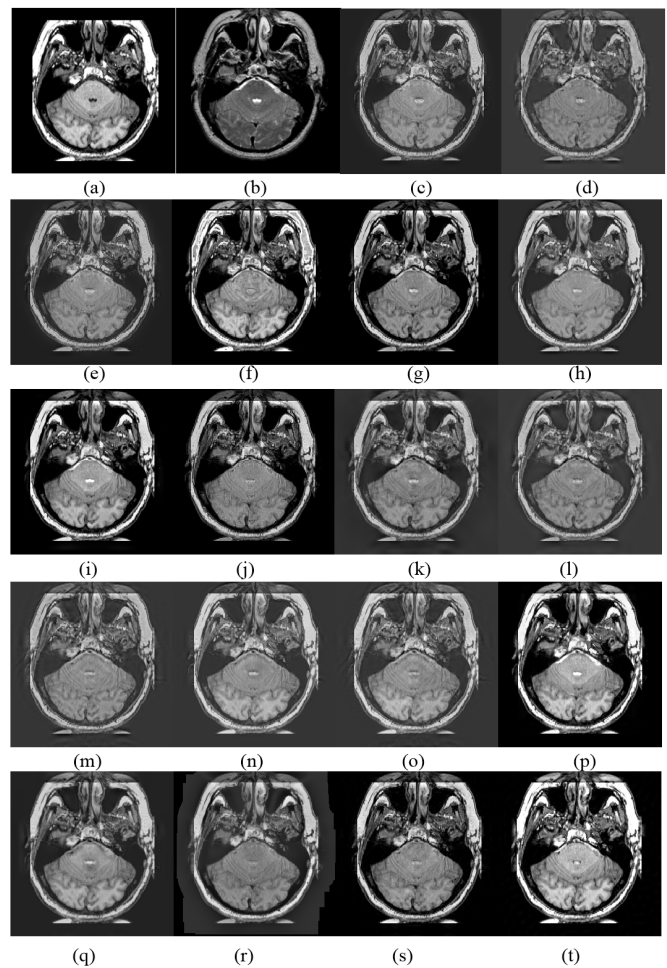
Experiments for S3. (a) CT. (b) MRI. (c) GP [52]. (d) DWT [52], [53]. (e) fsdP [52]. (f) GFS [54]. (g) CSR [55]. (h) ASR [56]. (i) GFF [57]. (j) MSVD [58]. (k) DTDWT [59]. (l) SWT [60], [61]. (m) CVT [62]. (n) DTCWT-SR [63]. (o) CVT-SR [63]. (p) LRSDL [64]. (q) PCLLE [65]. (r) MSGIF [66]. (s) DCHWT [67]. (t) Proposed.
